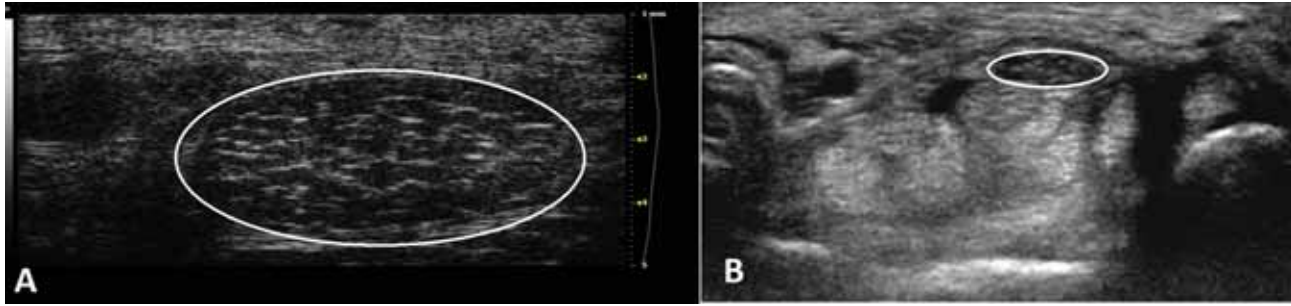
Ultrasonography of the median nerve at wrist.
